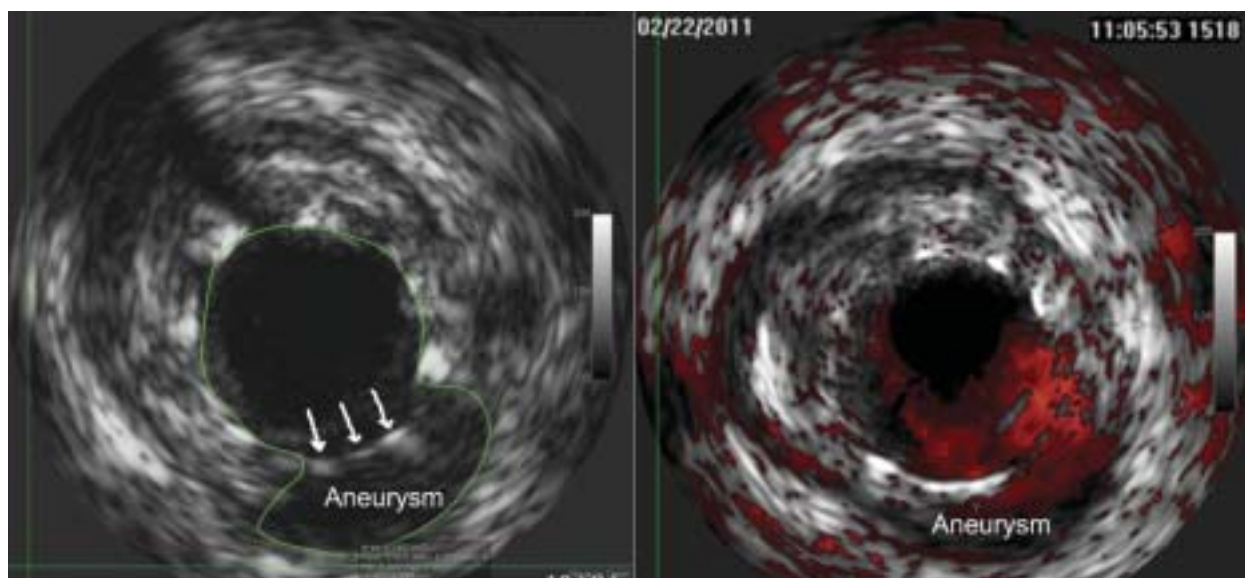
A coronary artery aneurysm in intravascular ultrasound. Arrows on the left indicate stent struts. A filling defect with intense echogenicity linked with the stent struts on the right suggests a thrombus
